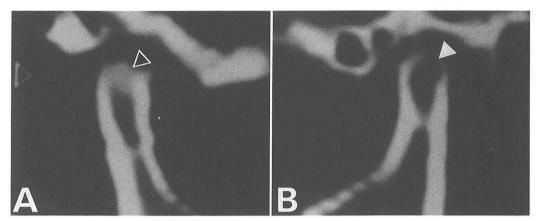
Sagittal CT scans. A, The right mandibular condyle shows sclerotic change of the bone (black triangle). B, The left mandibular condyle shows cortical osteolysis (white triangle).
